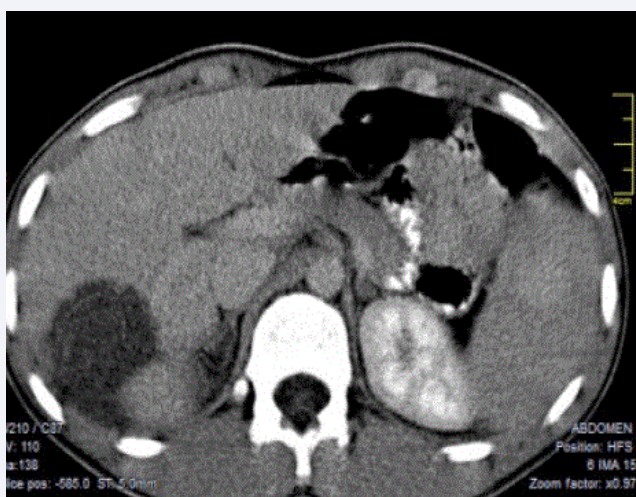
CT of the right lobe sided CHH.
